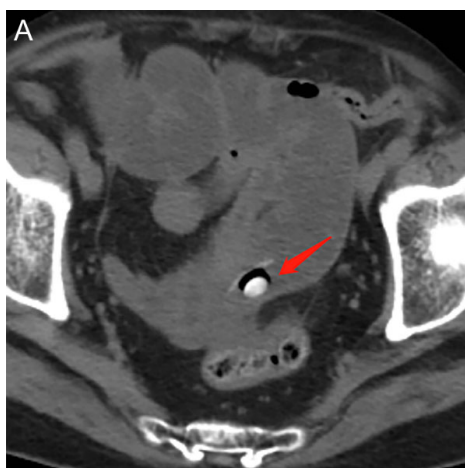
Abdominal CT tomography showed dilation and fluid accumulation in the small intestine, consistent with changes in the small intestinal obstruction. In addition, an irregular mixed-density shadow was observed in the pelvic ileum segment, with a strip-shaped high-density shadow at the top, an “air half-moon sign” change in the middle, and a nodular high-density shadow at the bottom.
